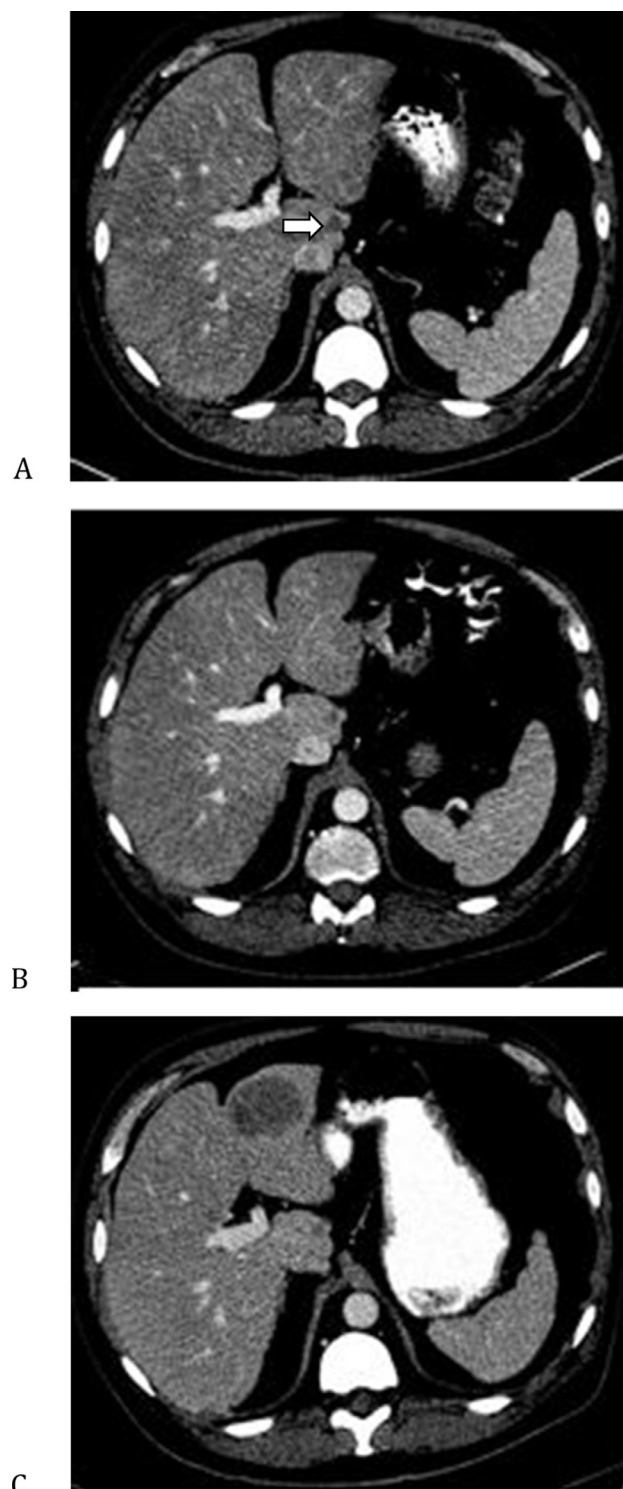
Computed tomography (CT) scan of the abdomen at baseline, after cycle 4 and at the time of progression after cycle 23 in the index case. The scan demonstrates a small liver lesion in the caudate lobe initially measuring 1.1×1.2 cm prior to treatment with M6620 and cisplatin (A, see white arrow). After 4 cycles of therapy, the lesion measures 0.8×1.0 cm (B). After completion of 23 cycles, a new, large anterior left hepatic lobe lesion measuring 4.5×4.1 cm is identified (C).
